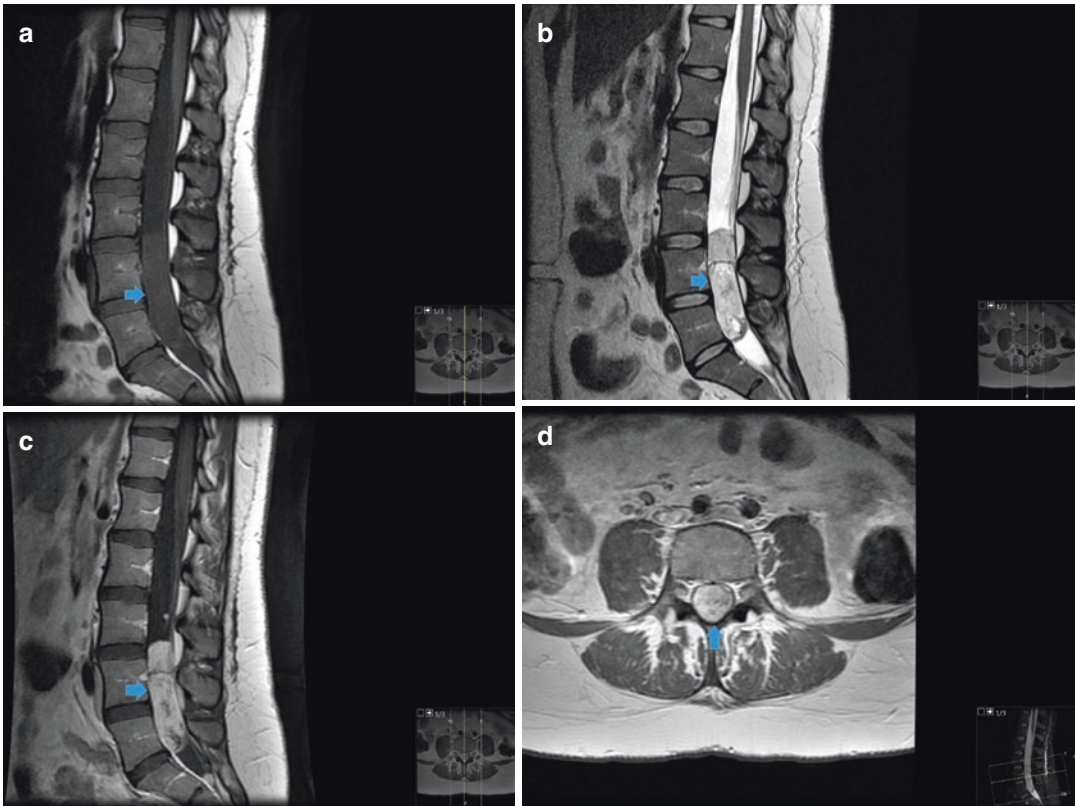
Myxopapillary ependymoma. Figure 9.12a is a sagittal T1-weighted MR image showing a large sausage-shaped isointense intradural extramedullary mass filling the thecal sac in the region of the cauda equina (arrow). The mass is heterogeneous and mildly hyperintense on the T2-weighted
